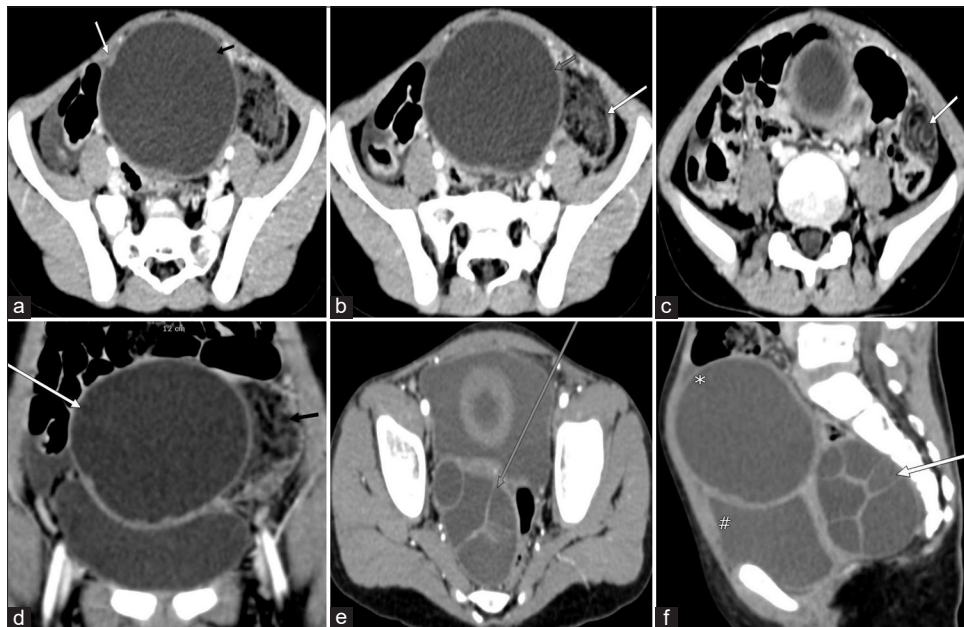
Computed tomography images demonstrating omental and pelvic cysts with associated omental torsion. (a) Axial contrast-enhanced computed tomography (CECT) showing omental cyst (black arrow) with wall nodularity (white arrow). (b) Axial CECT showing adjacent fat-density structure along the left lateral cyst wall (white arrow), suggestive of omental torsion. (c) Axial CECT demonstrating twisted omental vessels (white arrow) – the “whirl sign.” (d) Coronal CECT showing omental cyst (white arrow) and adjacent fat-density structure (black arrow) consistent with torsion. (e) Axial CECT image showing multiloculated rectovesical cyst (long grey arrow) with mass effect on the rectum and uterus. (f) Sagittal CECT demonstrating multiloculated rectovesical cyst (white arrow), omental cyst (*), and urinary bladder (#).
